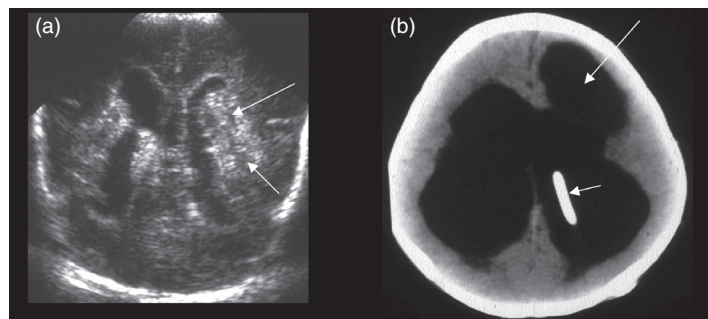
(a) Hyperechoic grade IV IVH with periventricular hemorrhagic infarction (arrows) on coronal US; (b) posthemorrhagic hydrocephalus with porencephaly (long arrow) on axial CT with shunt catheter (short arrow).
